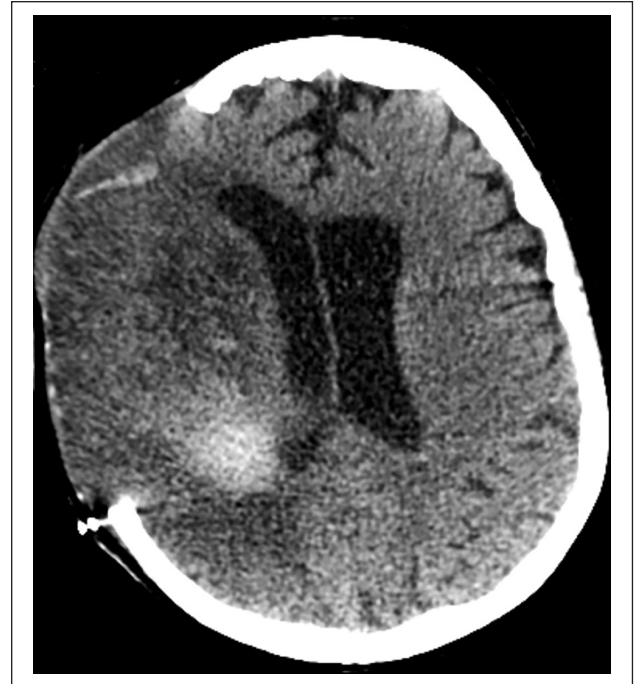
Head CTA axial section showing haemorrhagic transformation in the established infarct.
